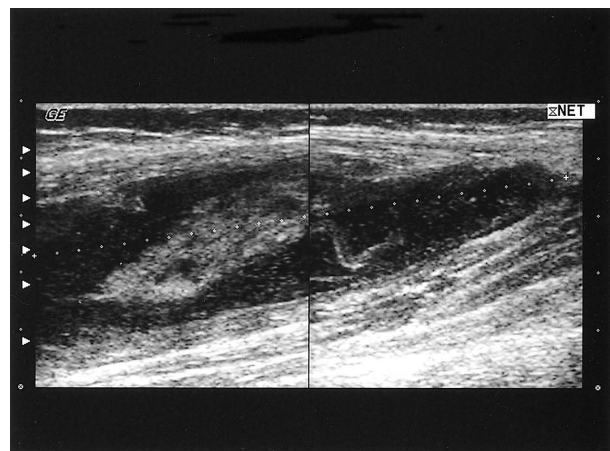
A $15 \times 3.5 \times 2.5$ -cm heterogeneous lesion with echogenic floating material is noted at the antero-lateral aspect of the right thigh on ultrasonography.
